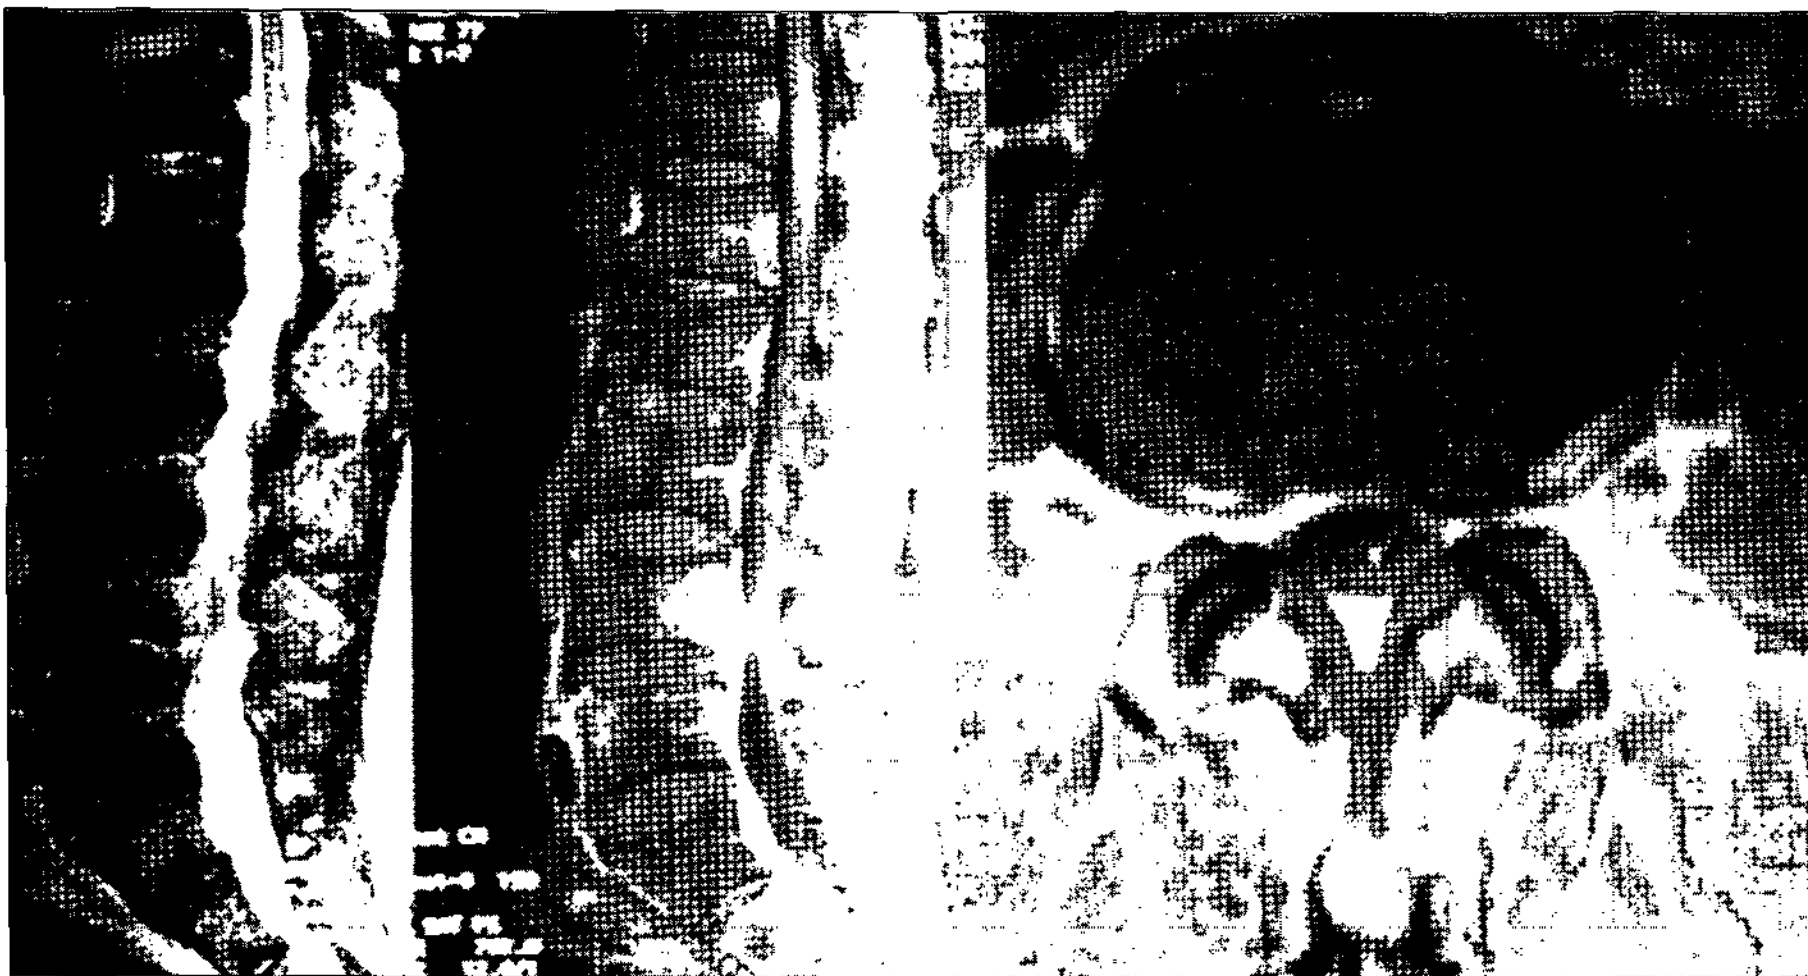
Tuberculous spondylitis (Type II). Magnetic resonance (MR) sagittal images demonstrate slight increase in the signal intensity of L4-5 intervertebral disc. Axial MR image demonstrate type II enhanced pattern.
